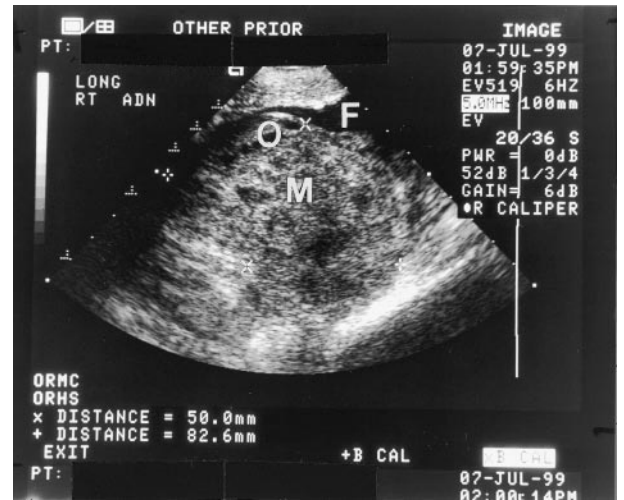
Sonogram from Case 2: Endovaginal longitudinal view of right adnexa, showing free fluid (F) and an 8.3 × 6.8 × 5.0 cm complex right adnexal mass (M) outlined by cursor [x +]. Ovary (O) at top.
